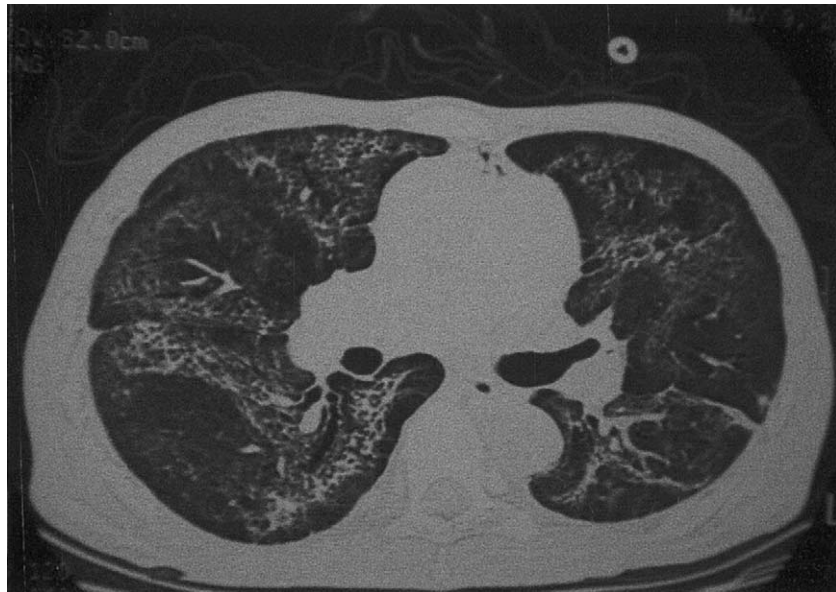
High resolution computed tomography of thorax 8 weeks after initial presentation. There is diffuse ground glass opacification, bilateral patchy consolidation, and fibrosis, features compatible with recovery phase of ARDS.
